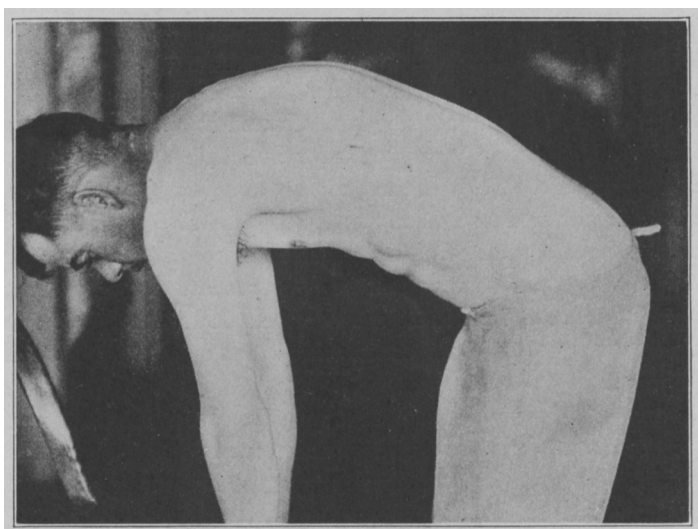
(Case 5).—Obliteration of the dorsolumbar curve. Roentgenographic examination revealed necrosis of the body of the fifth lumbar vertebra, which was probably tuberculous, the symptoms of which appeared after syphilitic infection.
